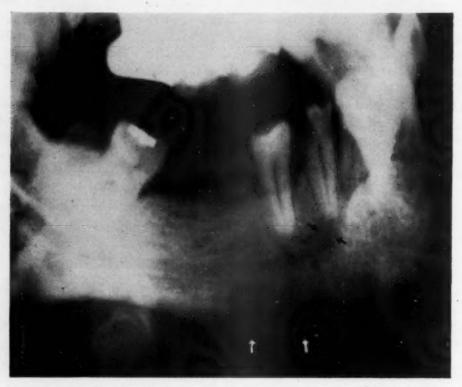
X-ray showing carious first premolar with periapical infection and osteomyelitis with sequestration at the inferior border of the mandible.
